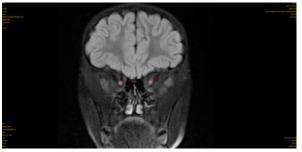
FLAIR IMAGE IN CORONAL SECTION showing bulky and heterogenous hyperintensity in optic nerve.
